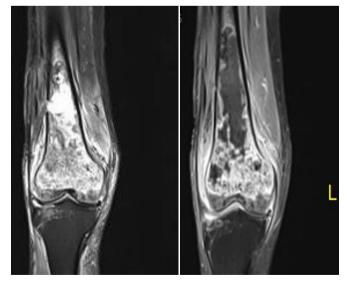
MRI of left knee shows early osteomyelitis of lower one third of femur surrounded by tissue swelling and effusion with intra medullary abscess formation.
